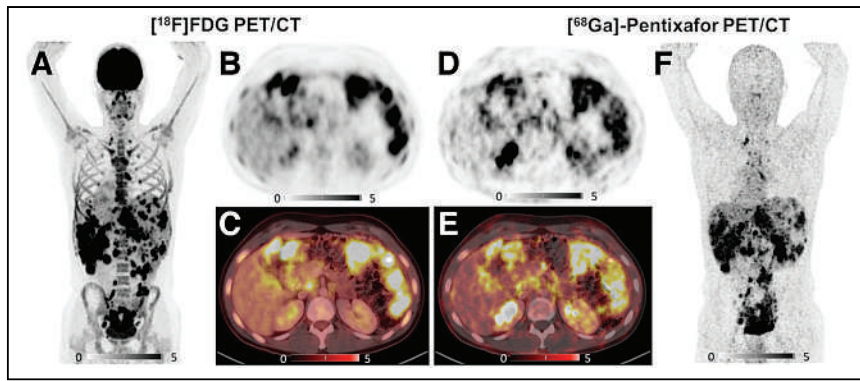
PET/CT scans with [⁶⁸Ga]pentixafor and [¹⁸F]FDG for patient 2. (A–C) [¹⁸F]FDG PET/CT shows intensive uptake in all tumor lesions (abdominal primary, lymph node, and hepatic metastasis) and moderate reactive uptake in bone marrow caused by chemotherapy. (D–F) In comparison, [⁶⁸Ga]pentixafor PET/CT demonstrates intensive and specific tracer accumulation in tumor lesions.
